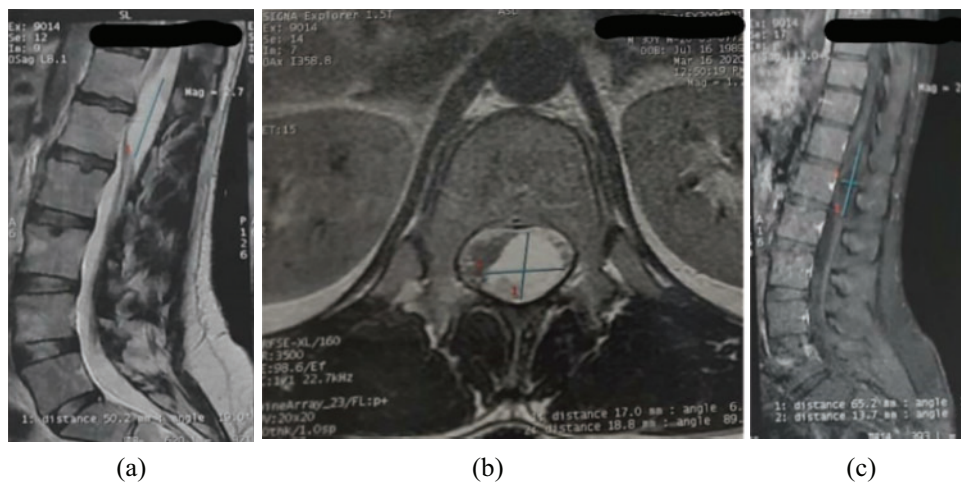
(a) Sagittal T2, (b) axial T2, (c) sagittal T1 with gadolinium: Dorso-lumbar MRI showing the lesion without any contrast enhancement in T1 and hyper-intense in T2.
